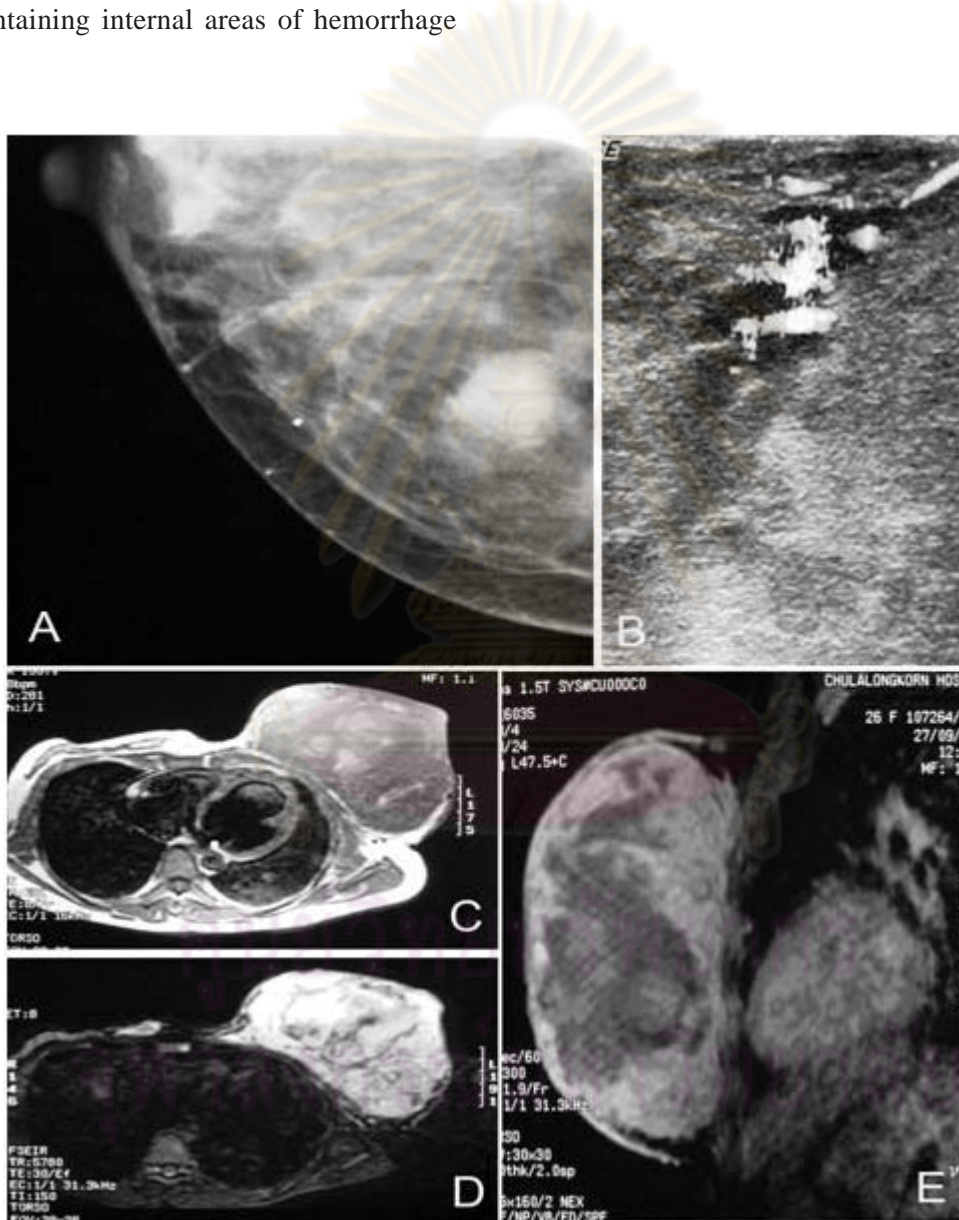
A: The mammogram showing a partially well-defined hyperdense lesion of the right breast; B: A hypoechoic mass with hypervascularity by color Doppler sonogram; C: Axial T1 weighted-image of the left breast demonstrating the mass having hypointense but internal areas of hemorrhage with hypersignal intensity; D: The hemorrhage areas and the whole mass exhibiting heterogeneous increased signal intensity on axial T2 weighted-image. Note that the right breast tumor shows hypersignal density; E: Sagittal view of post Gadolinium-enhanced dynamic study revealing enhancement of the mass except for the area of internal hemorrhage.
